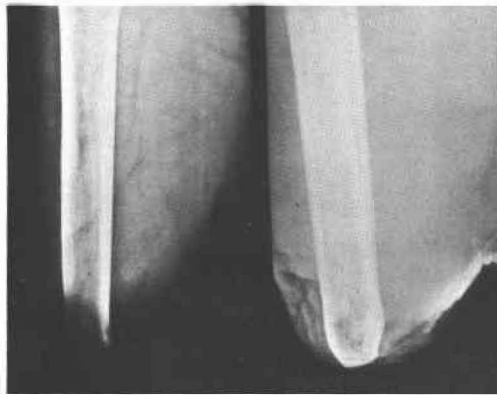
Two X-rays of the same above-knee stump. Left, standard exposure for the femur, over-exposed tip of the femur. Soft tissues only partially visible. Right, low contrast technique shows the whole of the femur and also the soft tissues. The quality of the soft tissues covering the bone and a skin ulceration on the medial side become visible.
